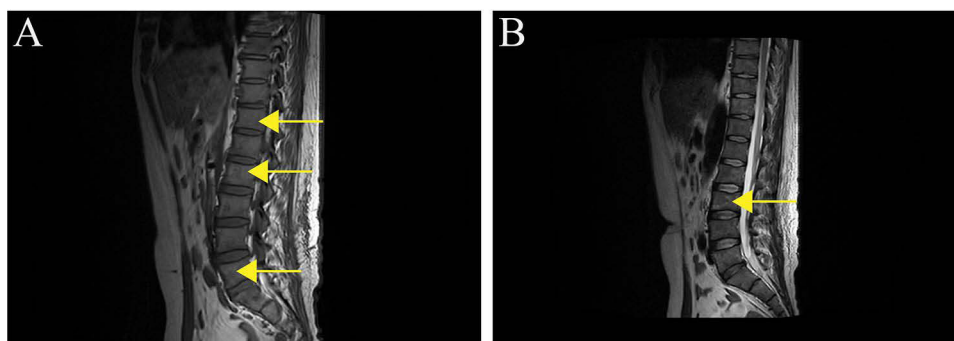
(A and B) Spinal MRI yellow arrows indicate that abnormal signals of the thoracic and lumbar vertebrae are significantly reduced compared with (Figure 3A and B).
